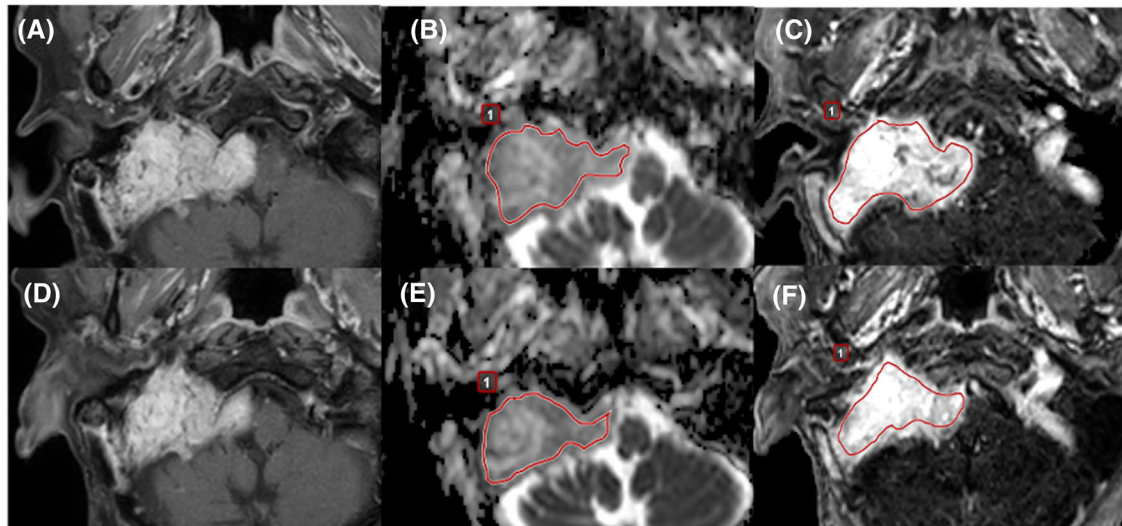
A 61-year-old male with paraganglioma in the right jugular foramen. (A) Post-contrast T1-weighted image, (B) apparent diffusion coefficient (ADC) map, and (C) permeability map demonstrate a pre-treatment paraganglioma in the right jugular foramen. (D) Post-contrast T1-weighted image, (E) ADC map, and (F) permeability map demonstrate a post-treatment paraganglioma. A freehand region of interest (ROI) is placed on (B) and (E) ADC maps, and pre- and post-treatment ADC values are calculated. Another freehand ROI is placed on (C) and (F) permeability maps, and quantitative parameters are calculated. In this case, the tumor regresses after external beam radiation therapy
